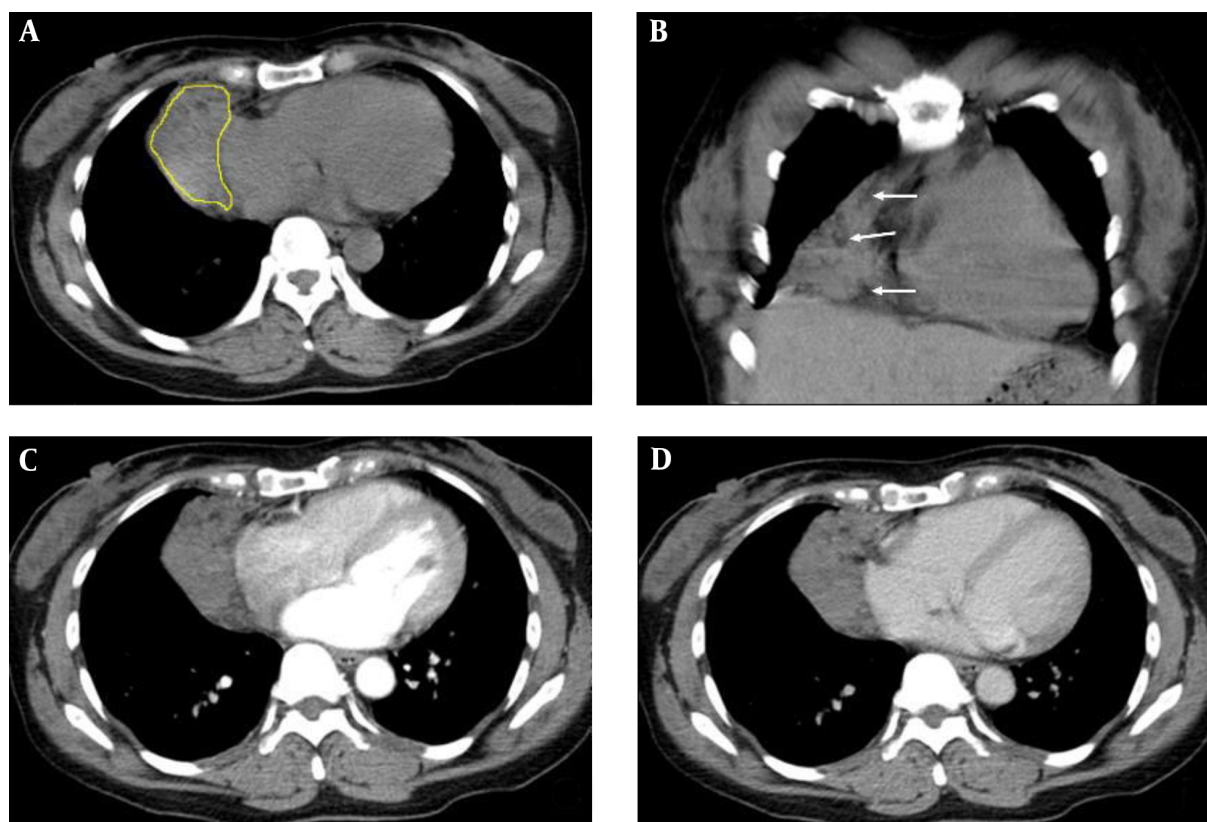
Transverse plain CT scan; A, an anterior mediastinal mass is shown with soft-tissue attenuation arising from the right CPA; no phleboliths or calcifications were observed; the outlined yellow area is a sample of ROI measured CT values. On coronal sections, B, the tumor had no capsule and appeared as an embedded growth pattern; the mass was closely related to the pericardium, with no evidence of invasion; there were discrete low-density areas representing fat in the tumor (white arrows). Transverse contrast-enhanced CT image (C and D for arterial and venous phases, respectively) showed non-enhancement within the tumor and no obvious feeding vessels to the tumor were identified.
